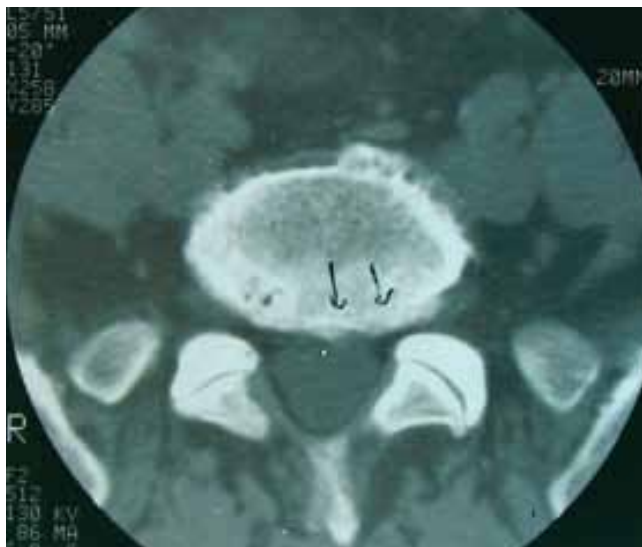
Preoperative CT revealed osseous stenosis of the left lateral recessus at the level L5-S1 caused by arthrosis of the facet joints and dorsal osteophytes.
